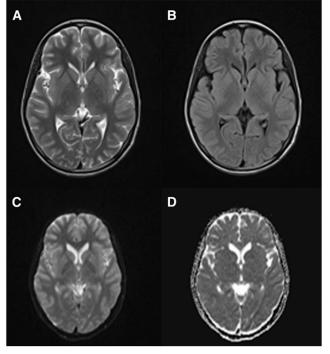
Magnetic resonance imaging of the brain of a child with dengue-triggered parkinsonism. T-weighted (A), fluid-attenuated inversion recovery (B), diffusion-weighted (C) sequences, and apparent diffusion coefficient map (D) does not show any basal ganglia or parenchymal abnormalities.
